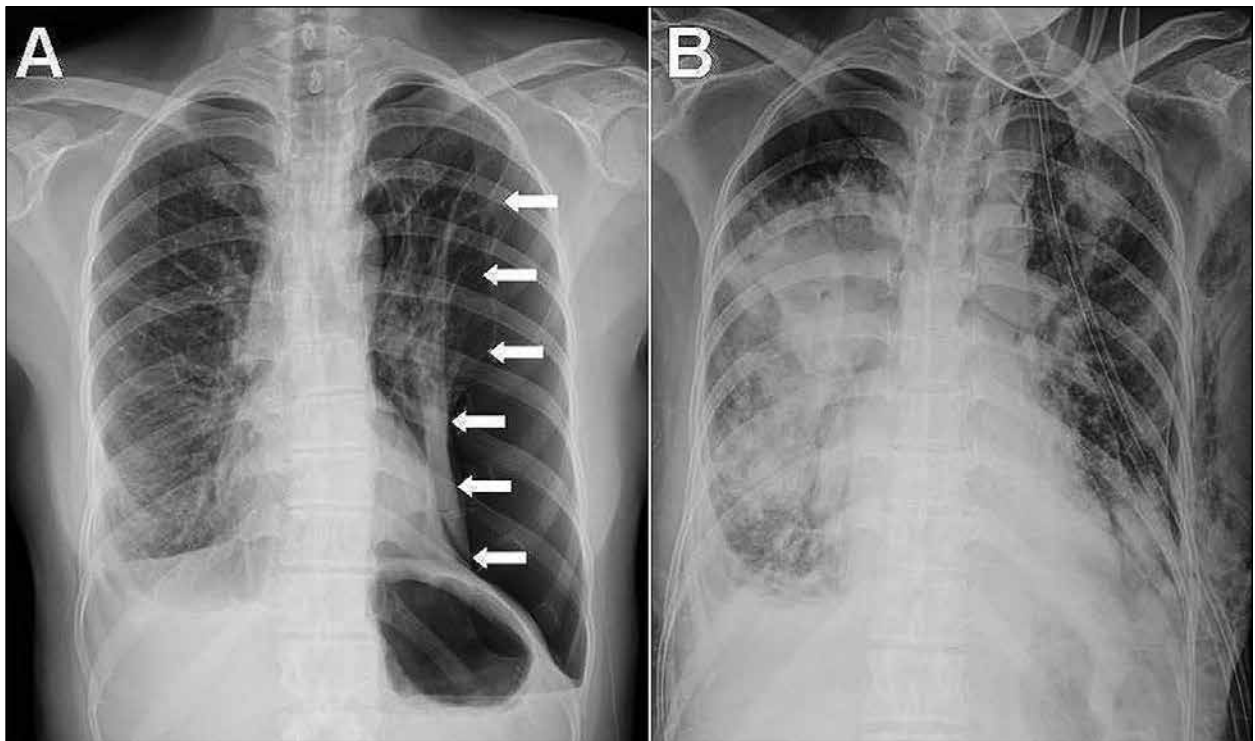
(A) Chest X-ray showing left pneumothorax with a totally collapsed left lung (white arrow) and (B) pulmonary edema of right lung after video-assisted thoracic surgery for left pneumothorax
